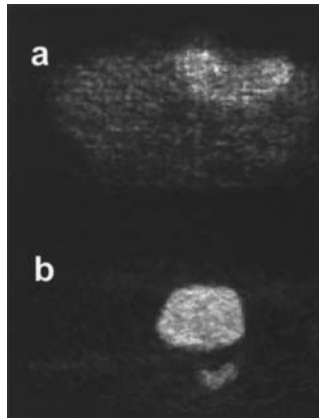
SUV images of the studies presented in Figs. 1 (a) and 2 (b).
